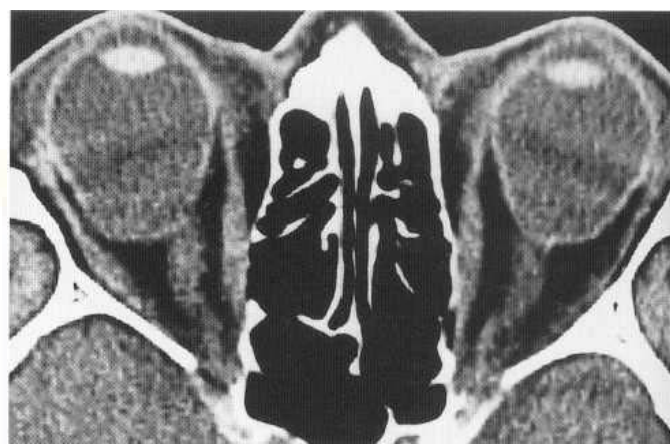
Coloboma. Axial CT image demonstrates bilateral retinal defects with outpouching in the region of the optic nerve head.
